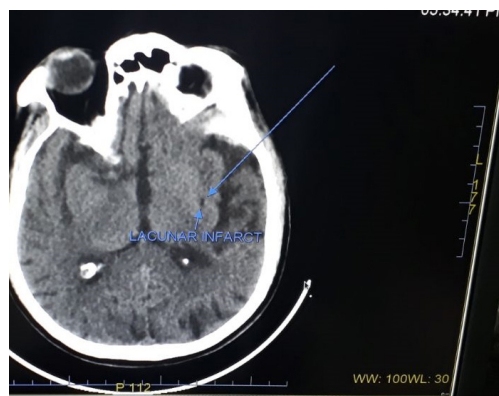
CT Brain showing acute infarcts in left capsuloganglionic area.
